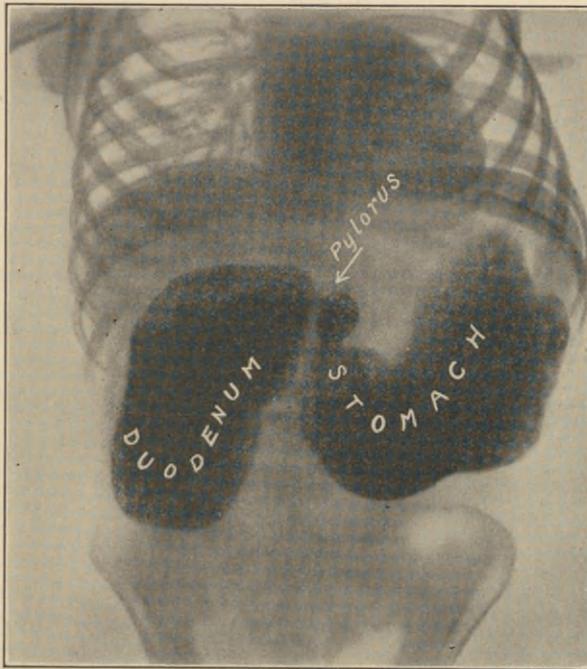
X-RAY PICTURE OF GIANT DUODENUM AND STOMACH OF A CHILD FOUR YEARS OF AGE. (Downes.)
